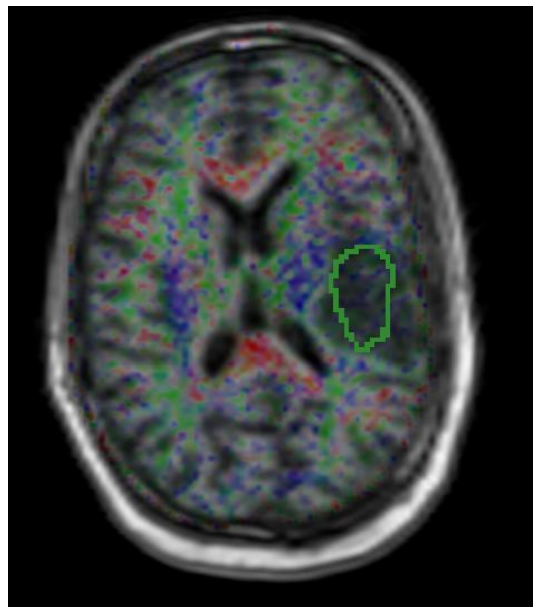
ROI of size of infarct drawn above and below the level of infarct on DTI image with FLAIR image overlapped for better anatomical delineation.
